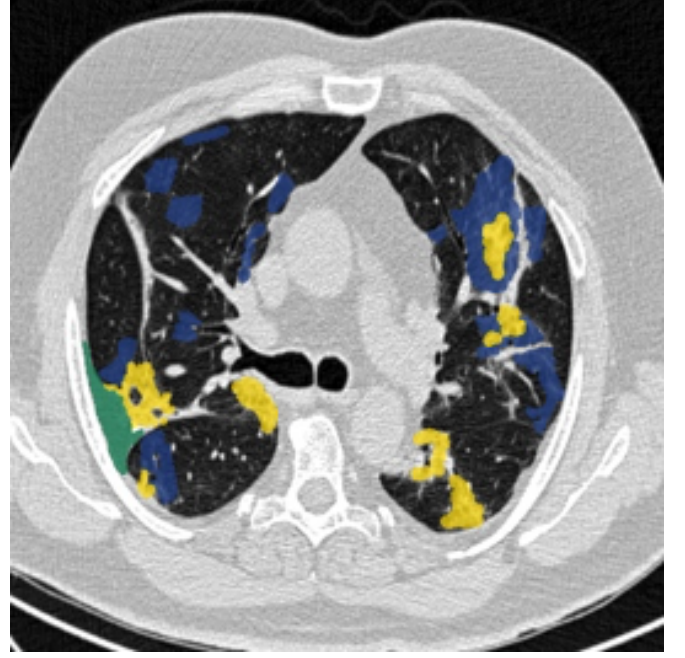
Annotated CT scan of a patient with laboratory proven COVID-19 pneumonia from the Italian Society of Medical and Intervention Radiology (SIRM). The RGB-values were “marked” into the image using a corresponding numbered mask label representing ground-glass opacities (GGOS) in blue, area of consolidation in yellow, pleural effusion in green and background.
